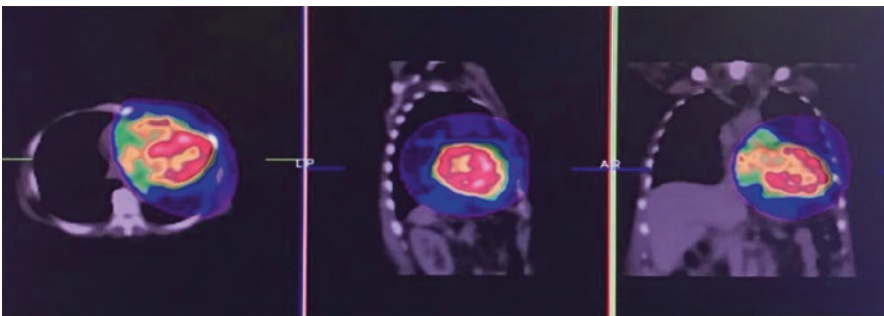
Fused SPECT/CT imaging (Author's personal archive)
